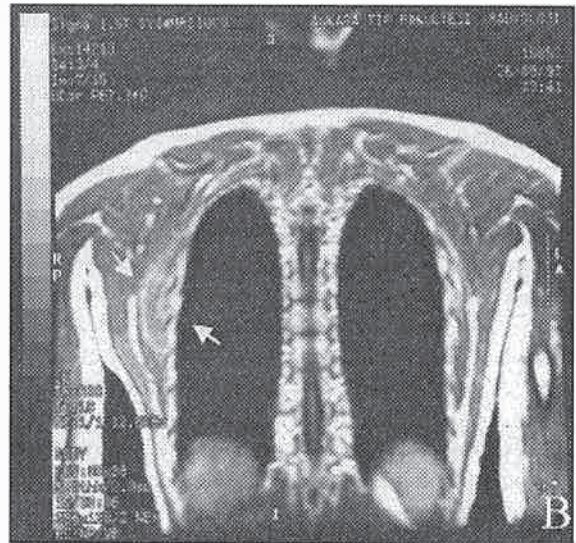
Mild linear enhancement was observed in the soft tissue mass following the injection of gadopentate dimeglumine on T1-weighted coronal
